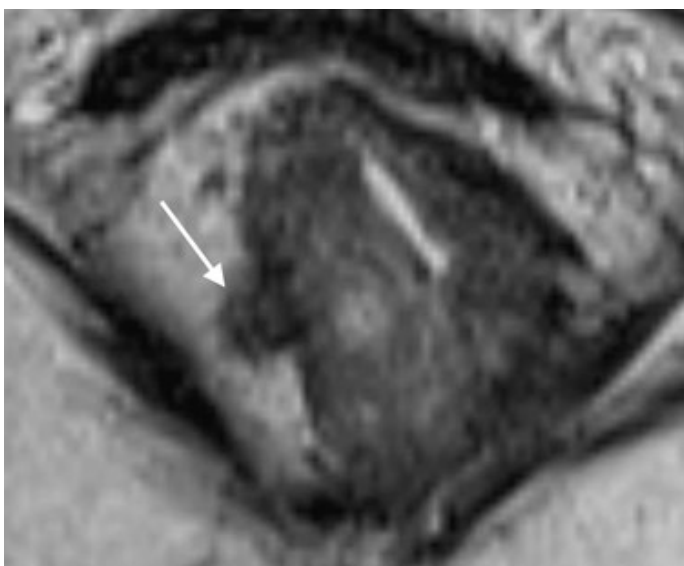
EMVI is readily appreciated on high-resolution T2 weighted MRI
